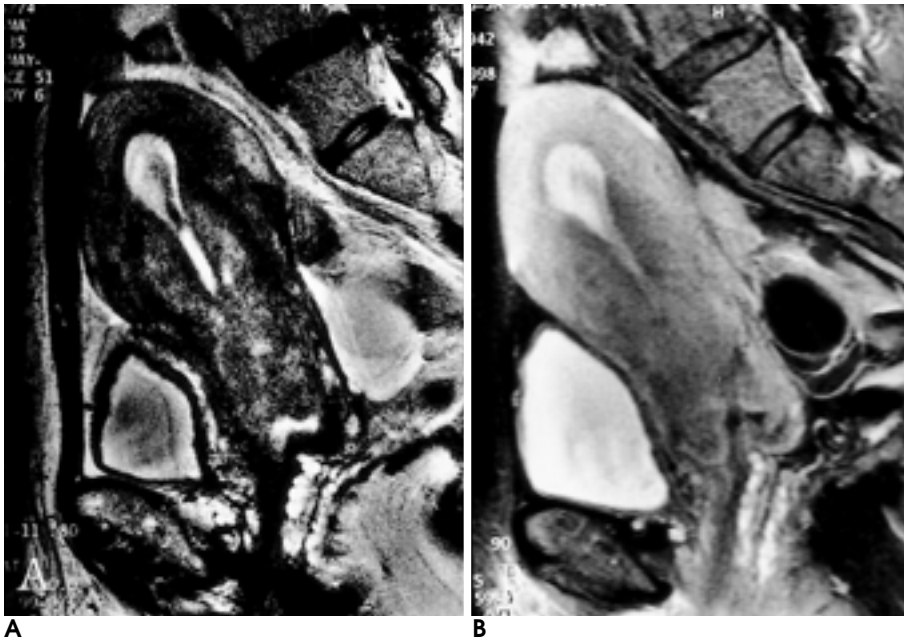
Cervical carcinoma involving uterine endocervix and exocervix shows invasion of the endometrium without destruction of junctional zone on sagittal T2-weighted image (A) and fat-suppressed Gd-enhanced T1-weighted image(B).
